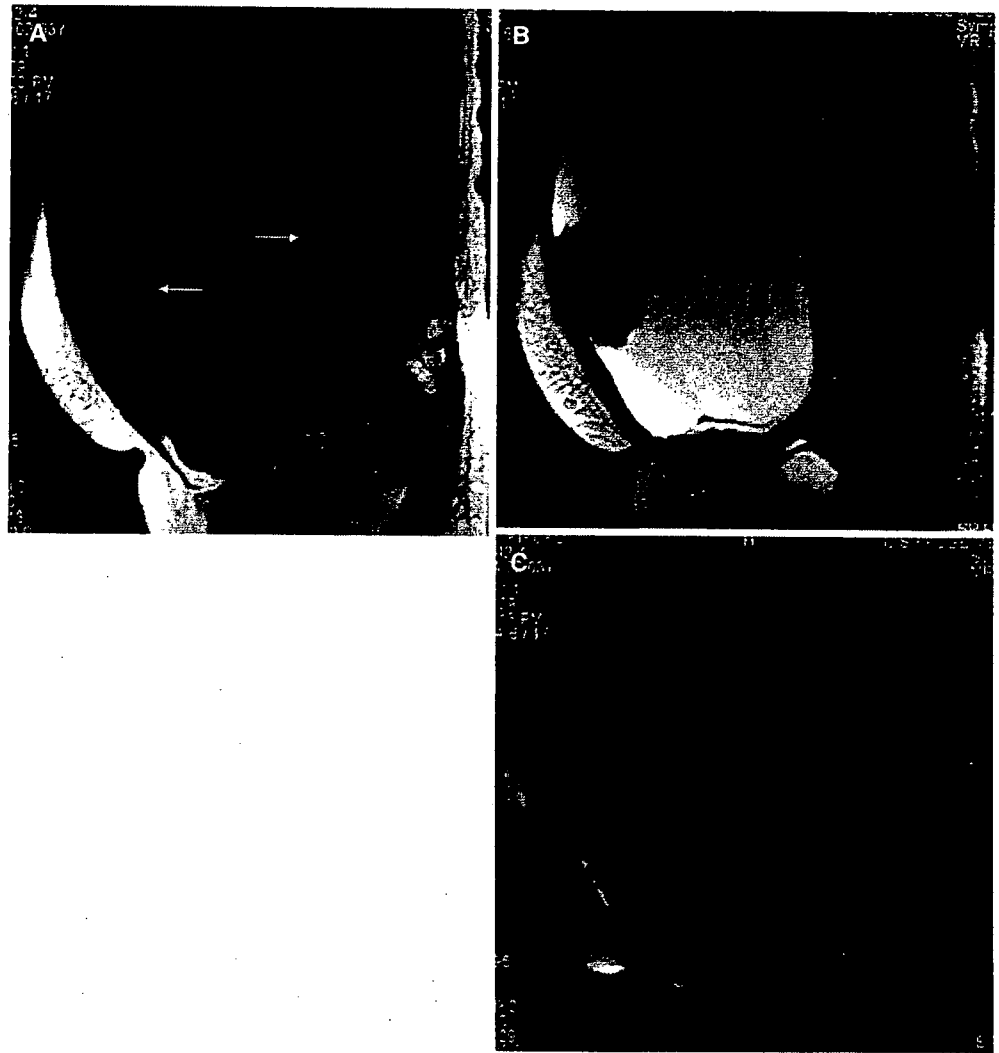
A 63-year-old woman of pT1cN0M0 (grade 1) with a preexisting endometrioma. A Sagittal spin-echo T1-weighted MR image (600/12) shows a 20-cm hypointense unilocular cystic mass with multiple isointense mural nodules (arrows), the largest of which measured 6 cm in diameter. B Sagittal turbo spin-echo T2-weighted (3500/92) MR image shows a very hyperintense unilocular cystic mass with multiple isointense mural nodules. C Fat suppression, gadolinium-enhanced sagittal spin-echo T1-weighted MR image (600/12) shows strong enhancement of the mural nodules
